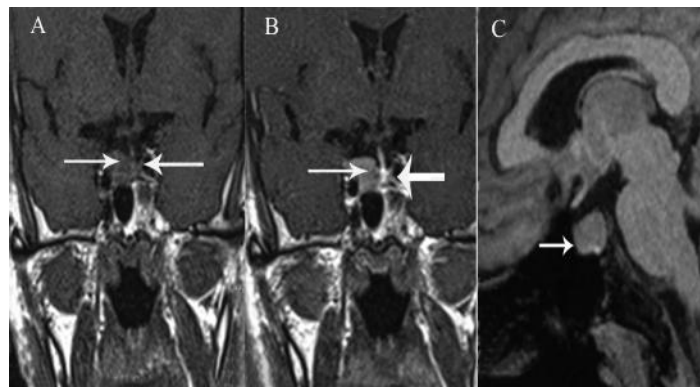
Panel A. MRI Brain T1 weighted post contrast image coronal section, showing a hypodense area in the right lobe of pituitary (arrow) suggestive of adenoma and early enhancement of the normal gland (arrow), Panel B. Showing a hypodense area on the right lobe of pituitary, with delayed enhancement (right sided arrows) suggestive of adenoma and normal gland on the left (left sided arrows), Panel C. MRI Brain T1 weighted images sagittal section, showing a hypodense area in the region of pituitary suggestive of adenoma
